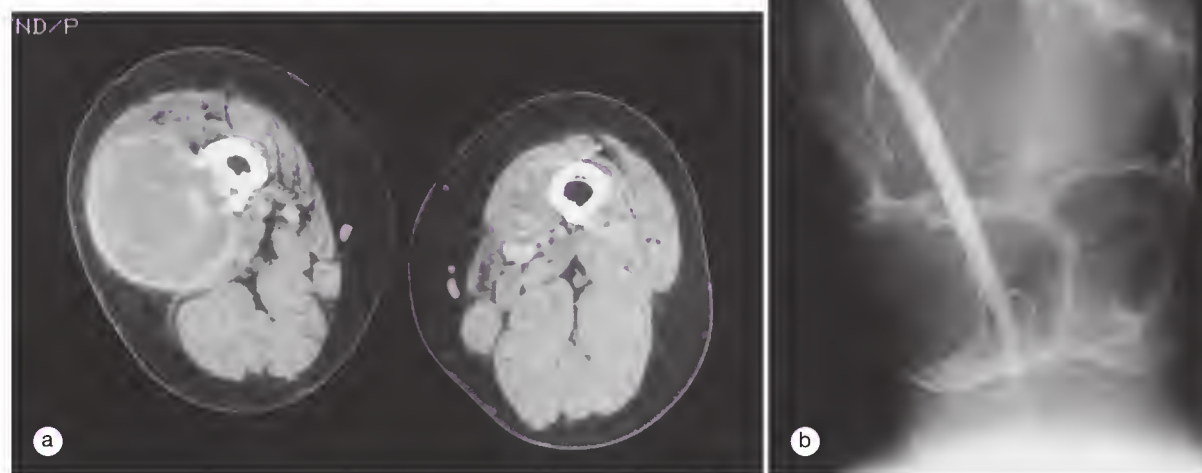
Pseudocyst of the femur. (a) Computed tomographic scan of a pseudocyst in the right femur. (b) Femoral angiogram showing a large pseudocyst of the femur.
